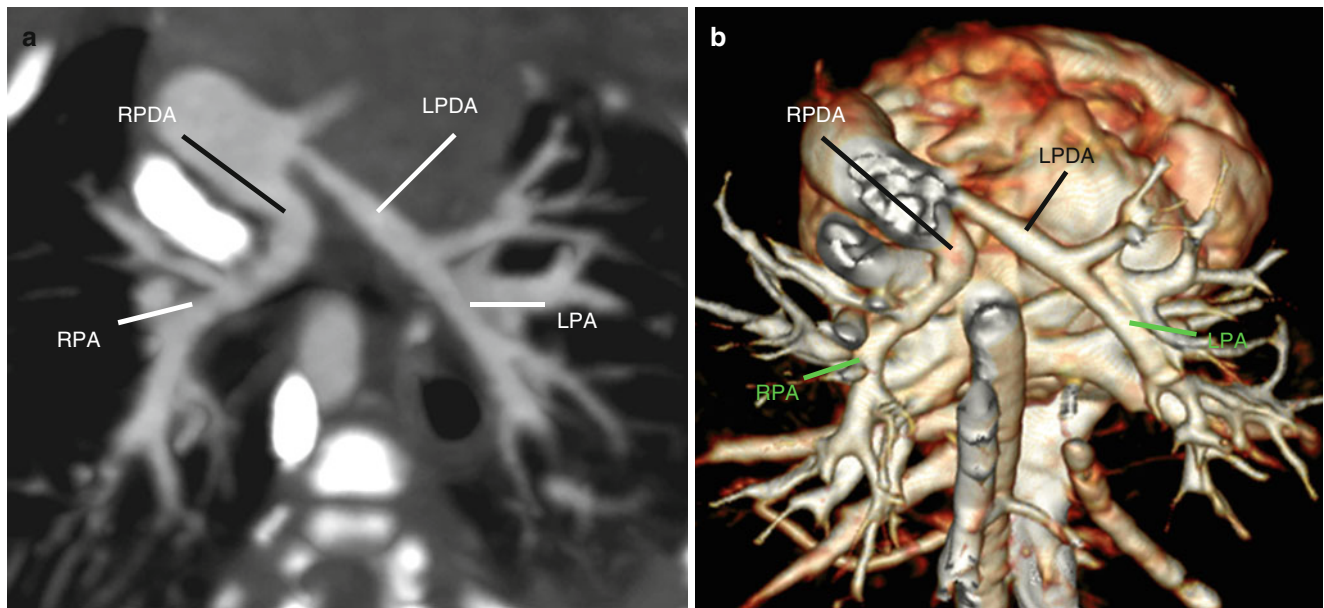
Pulmonary atresia with non-confluent central pulmonary arteries. Oblique axial CT image (a) and volume-rendered CT image (b) demonstrate that the right (RPA) and left (LPA) pulmonary arteries
